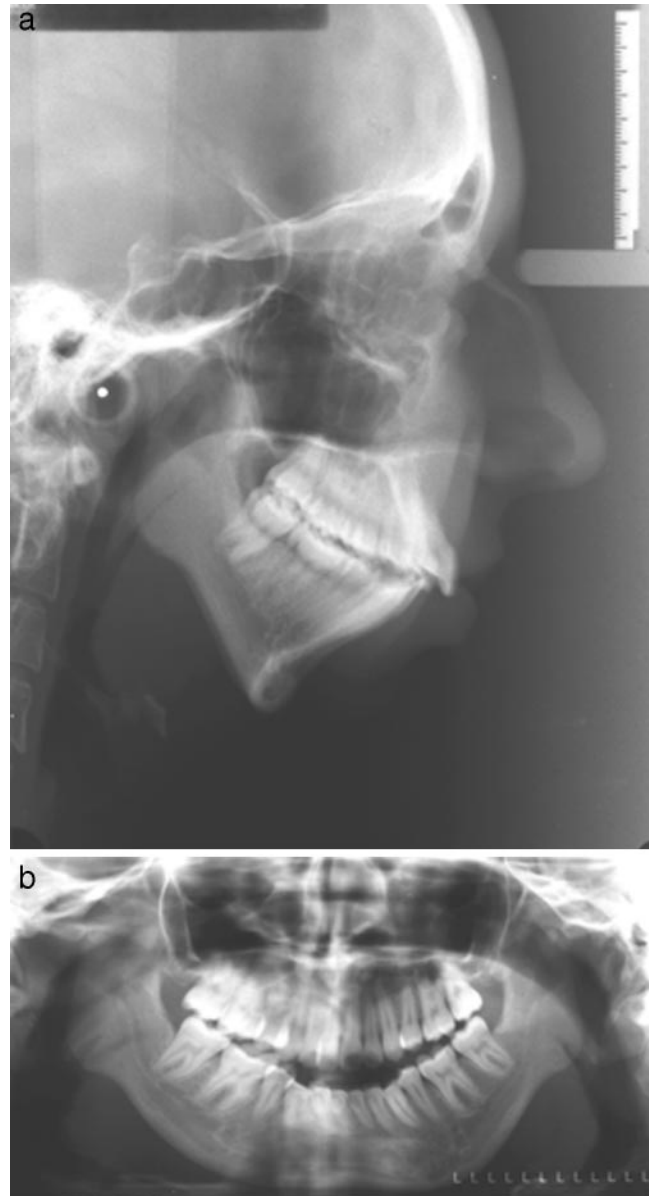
(a) Pretreatment lateral cephalometric radiograph. Note retrusive mandible with antgonial notching. (b) Pretreatment orthopantomogram. Note hypoplastic ramus condyle region.
